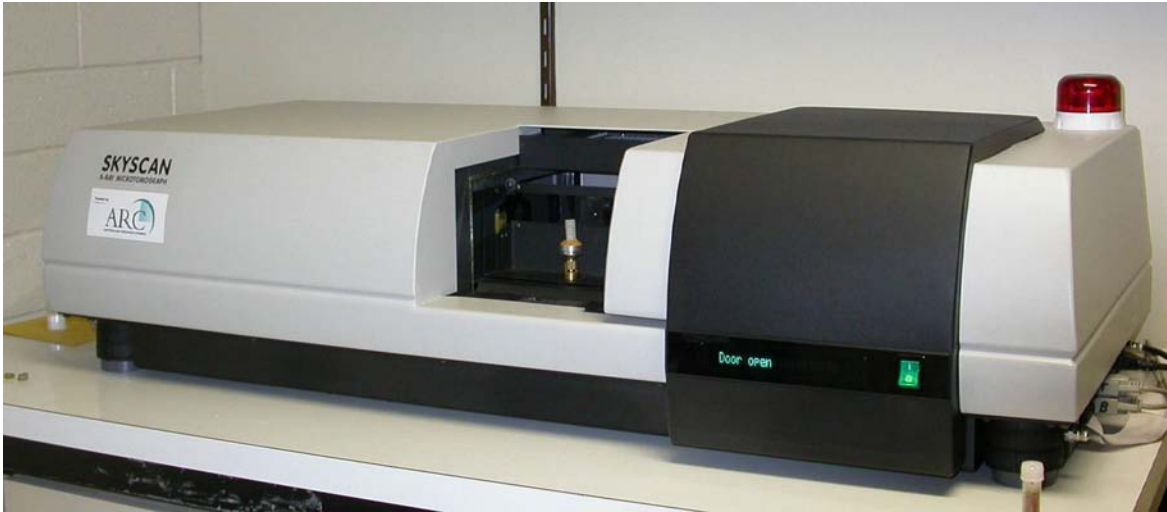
The SkyScan 1072, X-ray Micro-tomography system
